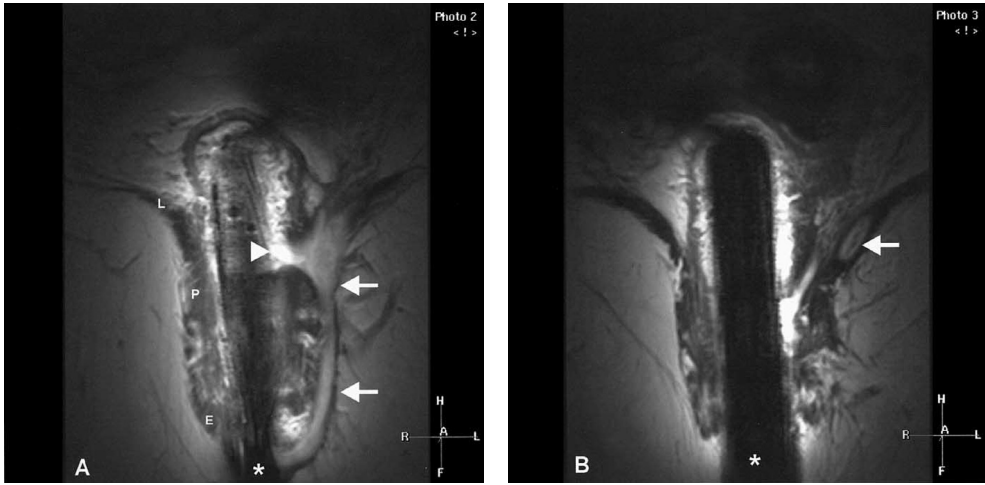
High trans-sphincteric fistula with secondary extension. (A) Coronal T2-weighted fast spin-echo endoanal MR image (TR/TE = 2443/100 ms) shows a high trans-sphincteric fistula (arrows) with the internal opening (arrowhead) at the level of the junction of the puborectal muscle (P) and the levator plate (L). E, external anal sphincter; endoanal coil (*). (B) On the next coronal slice one can see an extension of fistula (arrow) within the left sided levator ani muscle causing local thickening (compare with the right sided levator ani muscle). Endoanal coil (*).
